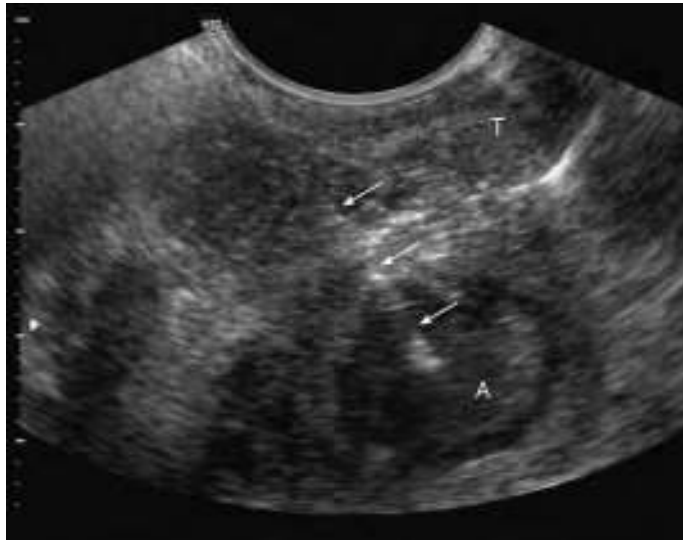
Intraoral ultrasound image. The needle (arrows) is inserted into the peritonsillar abscess (A). The tonsil (T) is visible on the top of the image. The internal carotid artery is not visualized in this image.
